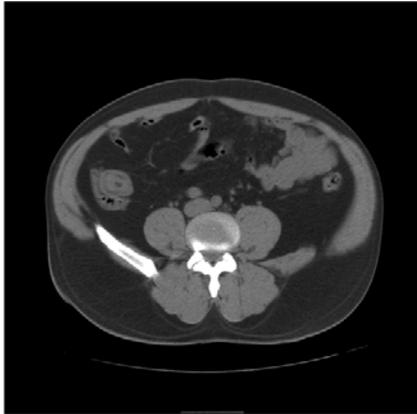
Ileal-Ileal Intussusception on an Axial CT View.
